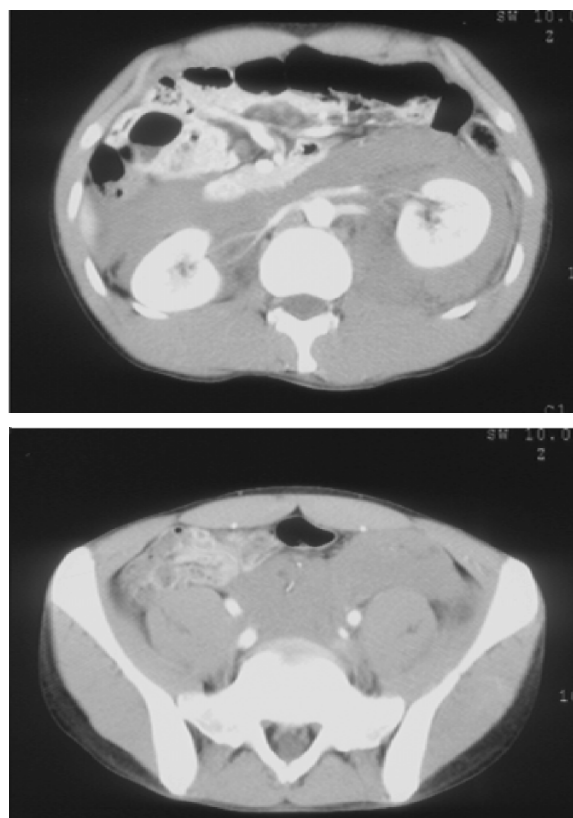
Abdominal computed tomography images revealing an extended retroperitoneal hematoma.
